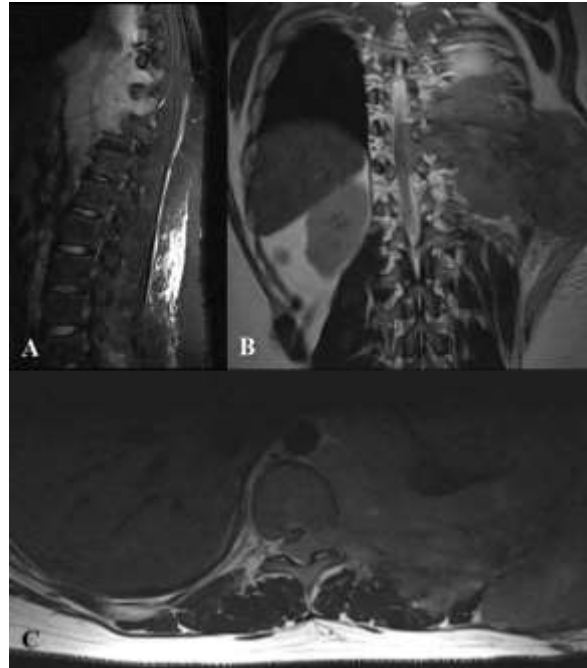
Paravertebral extension of Ewing's sarcoma in a 17 years old male patient. MRI - sagittal T2w TIRM (A), coronal T2w (B), axial T2w (C) large heterogeneous left chest wall mass associated with ribs destruction and incipient thoracic vertebral bodies involvement and extension to the spinal canal, the lesion is hypointense on T1w and hyperintense on T2w images. The left lung was compressed due to the mass effect.
